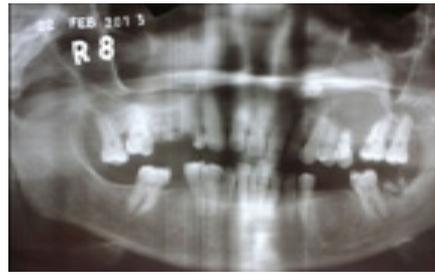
Diagnostic orthopantomograph showing the lesion
